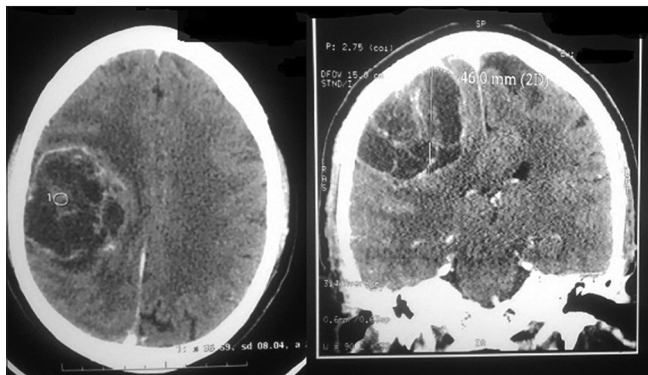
Contrast-enhanced computed tomography head showing well defined oval hypodense cystic intra-axial lesion with mild perilesional edema and mass effect; axial, coronal view
